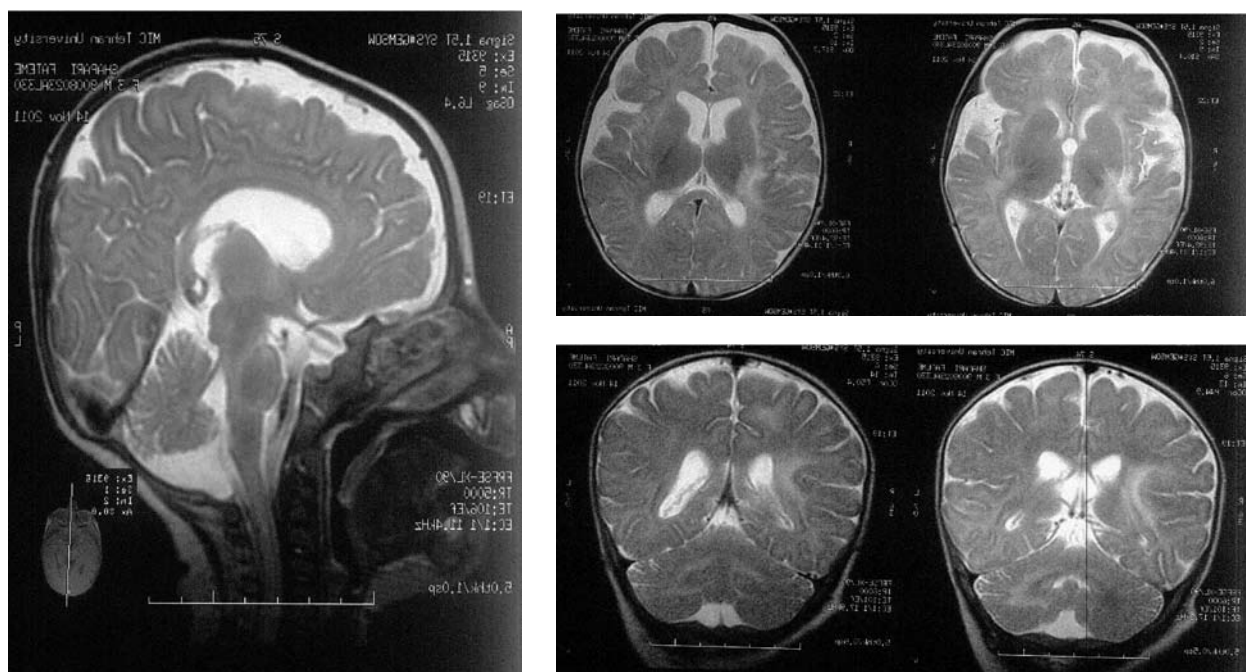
Magnetic resonance images of the brain before treatment, fluid-attenuated inversion recovery (FLAIR) sequence.
